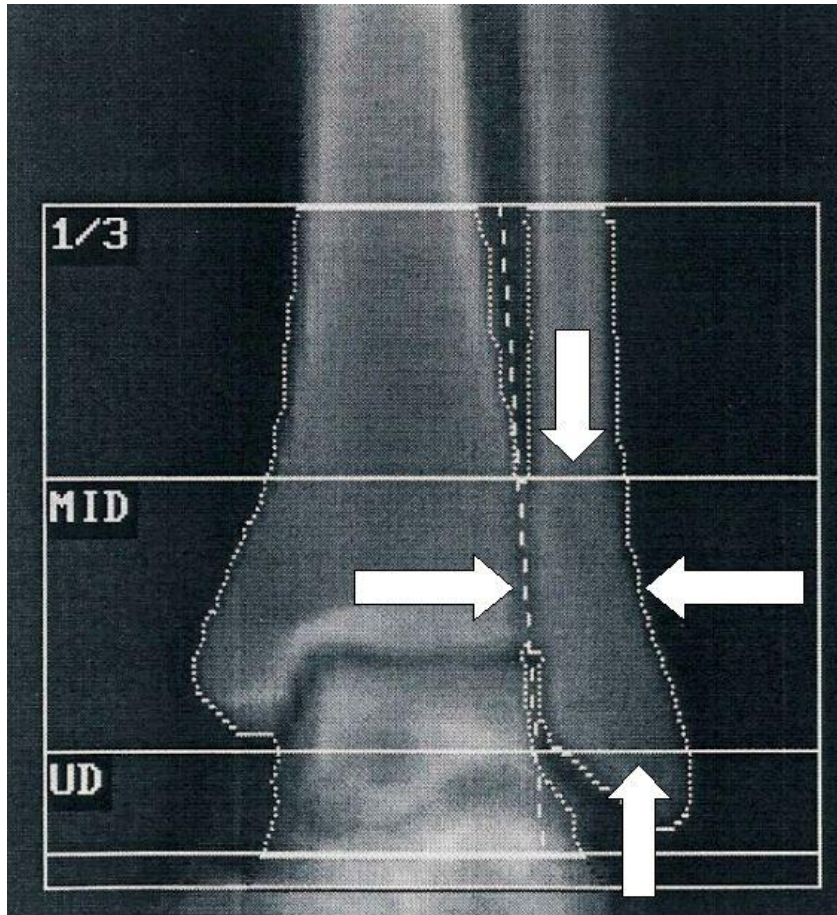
Bone mineral density in the lateral malleolus was measured with dual-energy X-ray absorptiometry. The area of interest (white arrows) in the distal fibula was determined to be 50 mm, starting 10 mm from the tip of the lateral malleolus.
